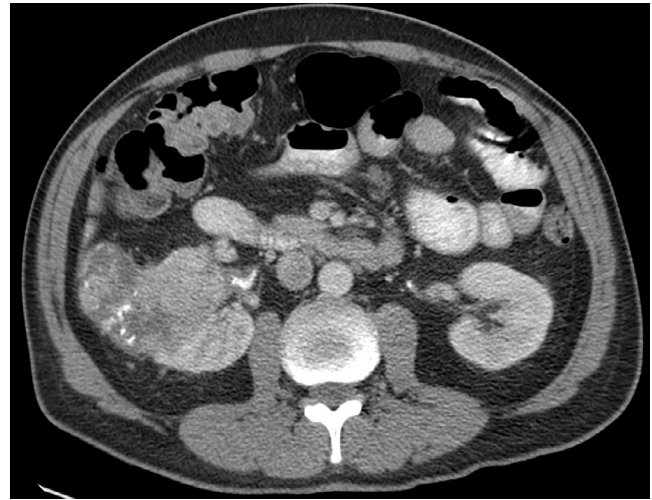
■ Calcified renal cell carcinoma. Post-contrast CT demonstrates a large soft-tissue mass in the right kidney with central calcification. Whilst peripheral calcification is commonly seen in cysts and benign lesions, central calcification is usually seen with malignant lesions.
